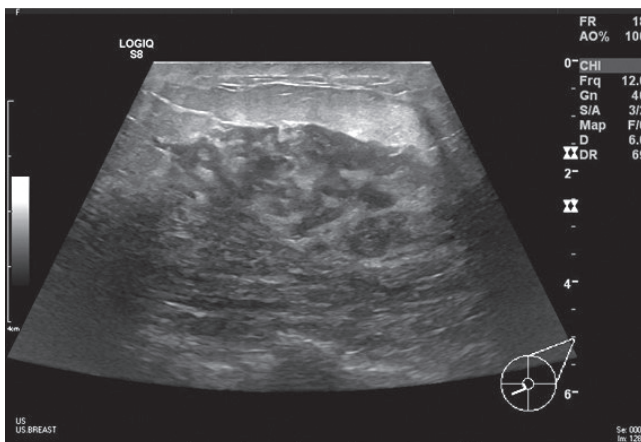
Ultrasonography of the patient's left breast lesion. An ill-defined hypoechoic lesion in the lower inner quadrant.
